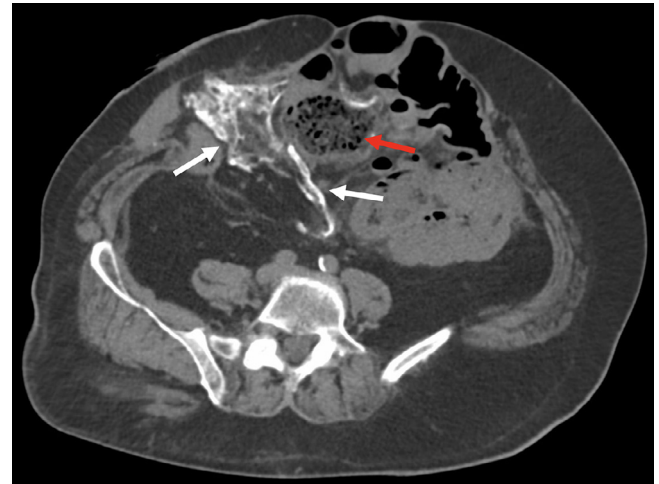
Matured HMO. Transaxial CT scan 10 months following the initial presentation demonstrates progressively mature ossification throughout the mesentery. It is peripherally hyperdense, with central low attenuation (solid white arrows). Distended loops of small bowel, including loops of bowel containing fecal-like matter and air-fluid levels, are also visible consistent with small bowel obstruction (solid red arrow). The bowel appears clustered in the central abdominopelvic region.
